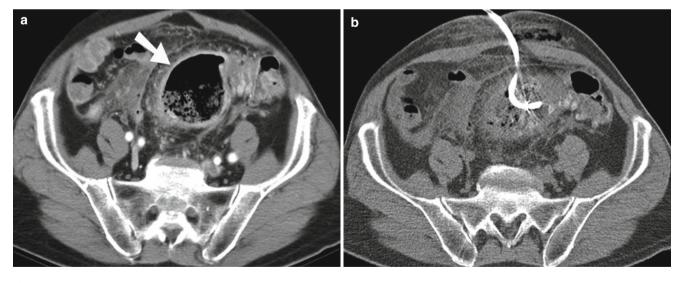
Diverticulitis abscess. (a) Contrast-enhanced CT scan study of the pelvis demonstrates a well-defined abscess cavity (*arrow*) in the sigmoid mesocolon with surrounding inflammatory changes. (b)
